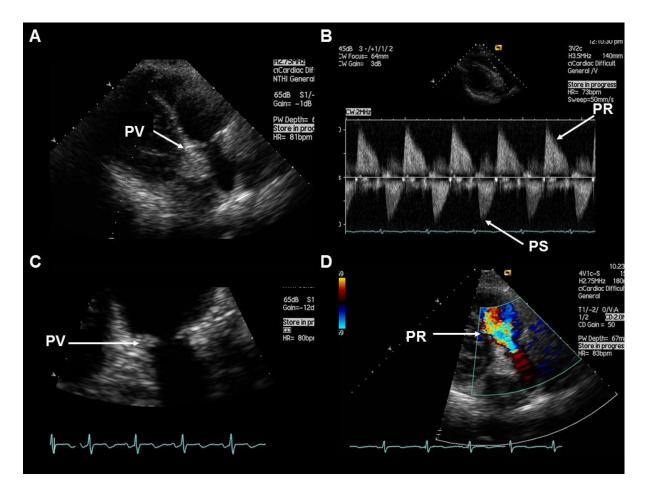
Carcinoid Involvement of Pulmonary Valve (PV) A. Right ventricular outflow tract. Thickened, fixed and retracted pulmonary valve leaflets that do not coapt. B. Continuous Wave Doppler of pulmonary valve shows pulmonary regurgitation (PR) with short deceleration time and pulmonary stenosis (PS). C. Parasternal short axis view of pulmonary valve. Shortened and retracted valve leaflets. D. Colour Doppler in diastole demonstrates turbulent pulmonary regurgitant flow.
